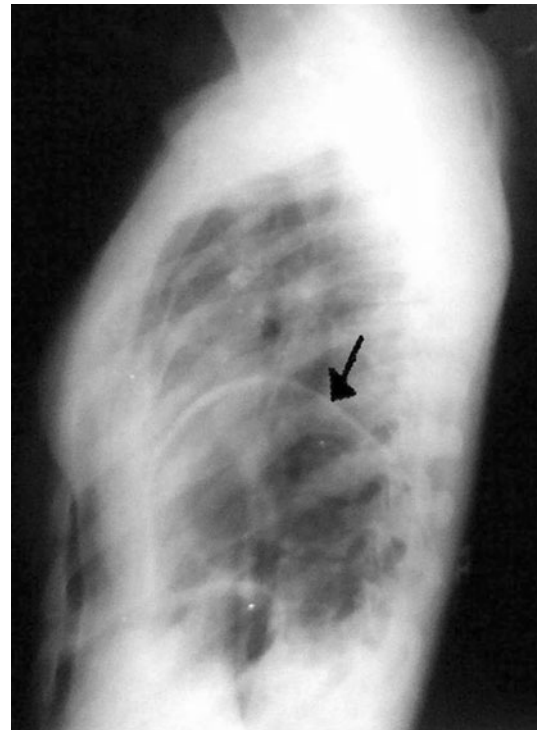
Left lateral chest radiograph showing left elevated hemidiaphragm with fundic bubble (*arrow*)
